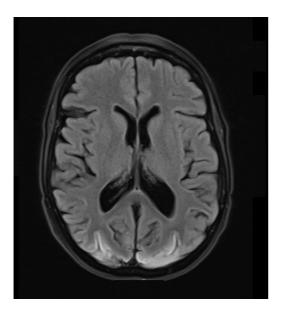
MRI brain scan showing bilateral occipital cortical signal abnormalities representing cortical pseudo-laminar necrosis as a sequelae of PRES.
